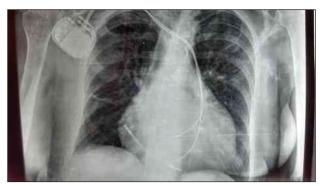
Thorax radiography demonstrating the positioning of the atrial and ventricular leads at the conclusion of the procedure.
